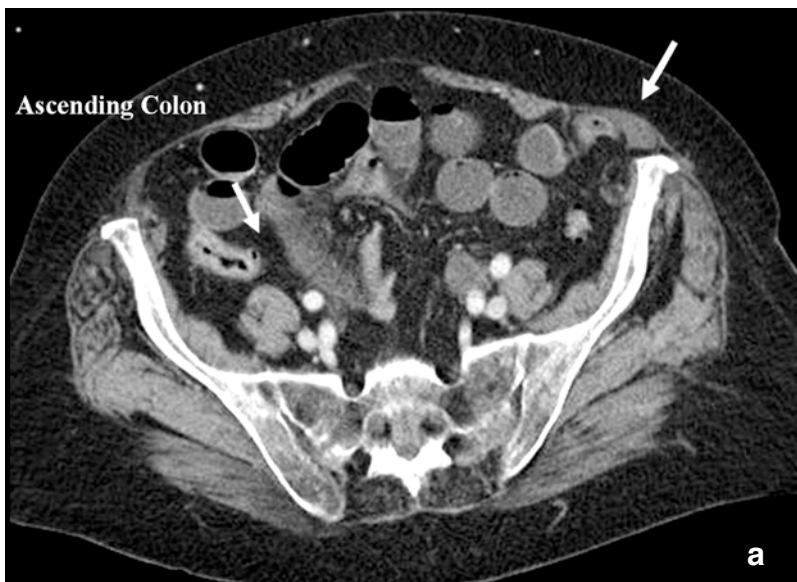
On axial CT images a) wall thickening and edema of a small bowel segment and edema of the transverse abdominis muscle is shown, in b) collapse of the respective bowel segment is detected, whereas all other segments of the small bowel are distended and fluid filled with several air-fluid levels. The collapse of the ascending and descending colon is indicative of an obstruction at a more orally location.
